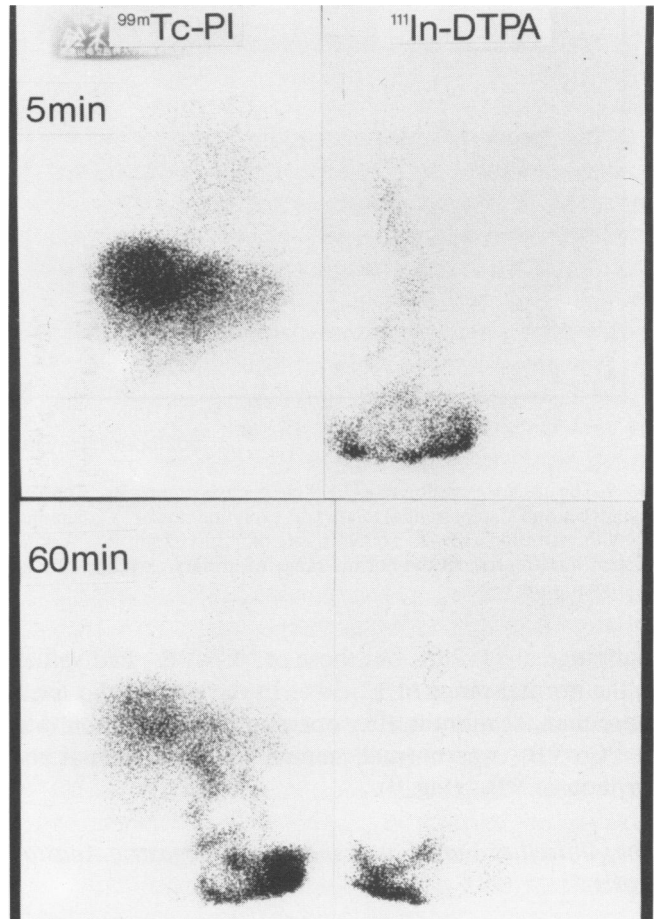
Hepatobiliary and alimentary scintigrams in the patient who lived 3 years after operation with cervical anastomosis. The radioactive substance in the stomach went down into the bowels already within 5 minutes after the administration.
